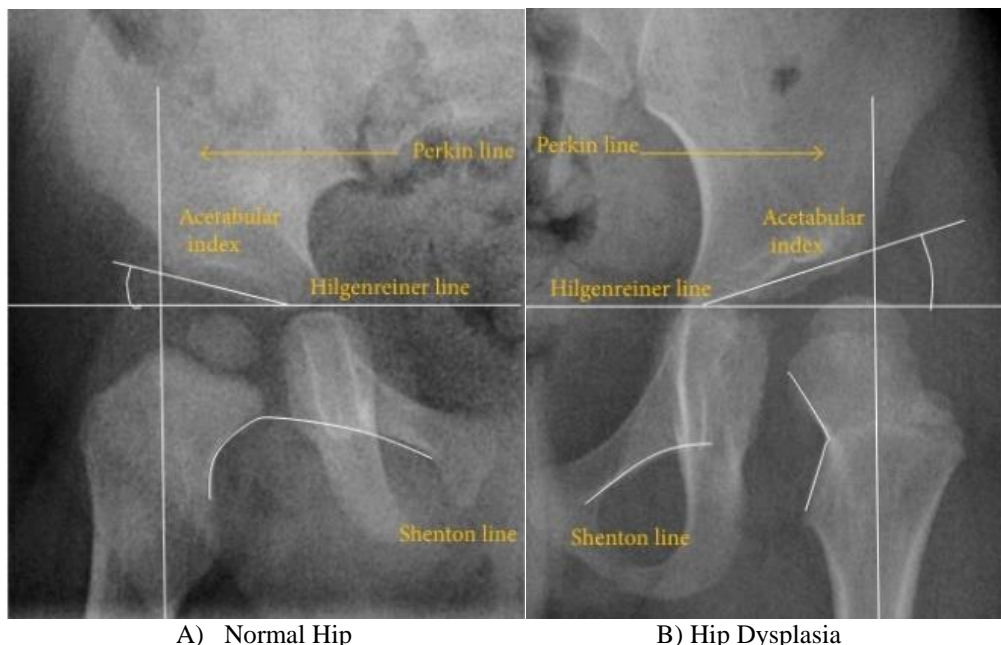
Showing the pelvis X-ray of a (A) normal hip & (B) hip dysplasia [26]
